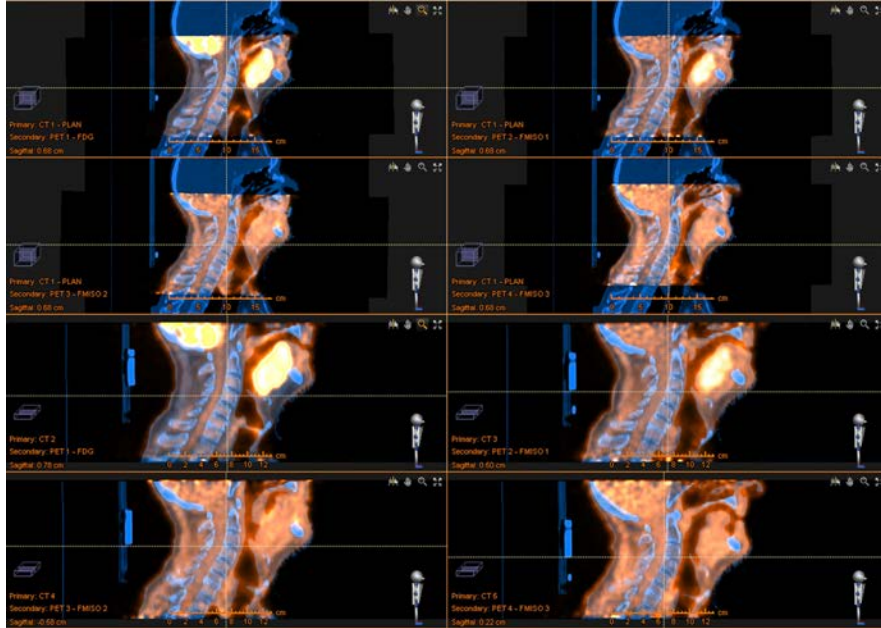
Example of hybrid registration (Patient 22). From top to bottom, left to right: planning CT overlapped with PET FDG, PET FMISO 1, PET FMISO 2, PET FMISO 3; CT-PET FDG; CT-PET FMISO 1; CT-PET FMISO 2; CT-PET FMISO 3, respectively.
